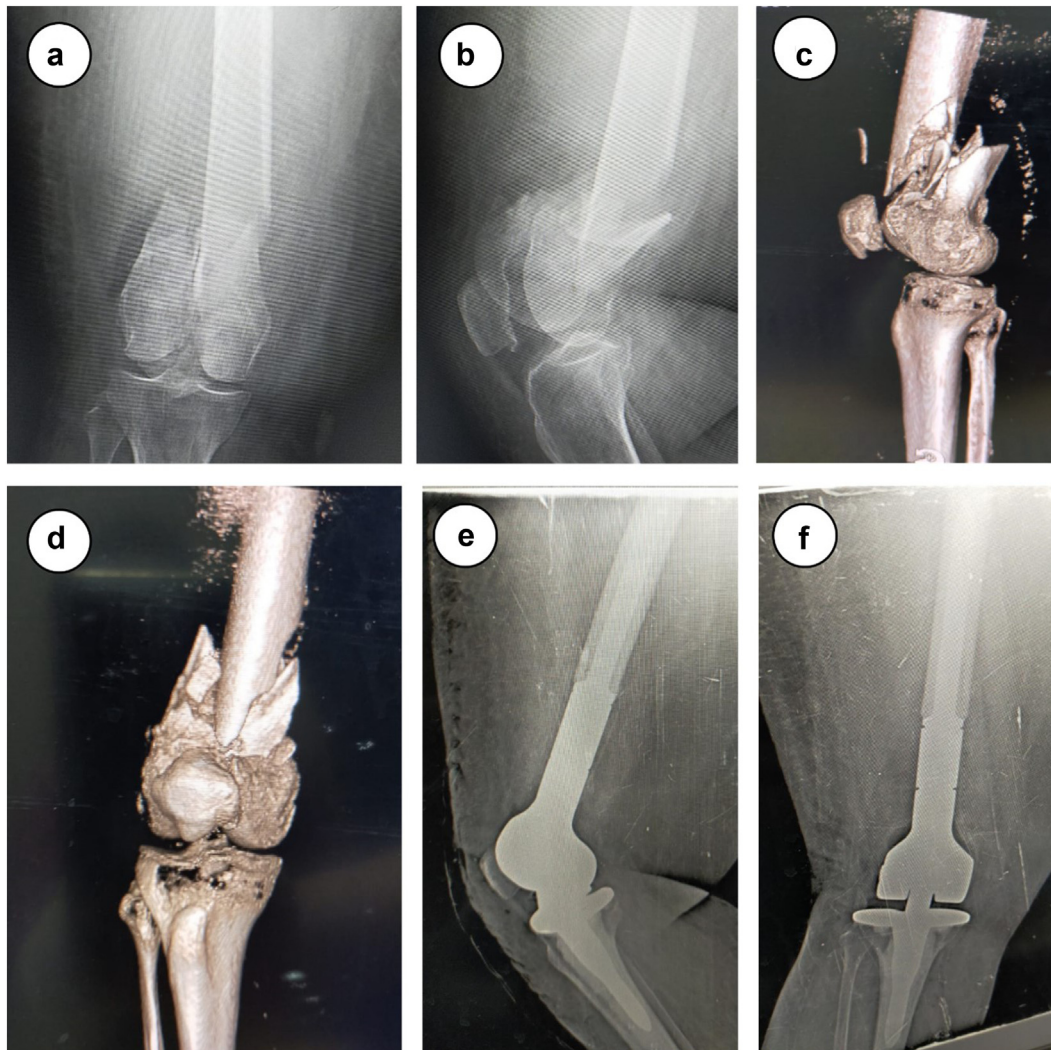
Example of a case with 33 C2 fracture was managed by DFR. (a and b) Anteroposterior and lateral plain radiographs; (c and d) computed tomography with 3D reconstruction; (e and f) postoperative radiographs.
